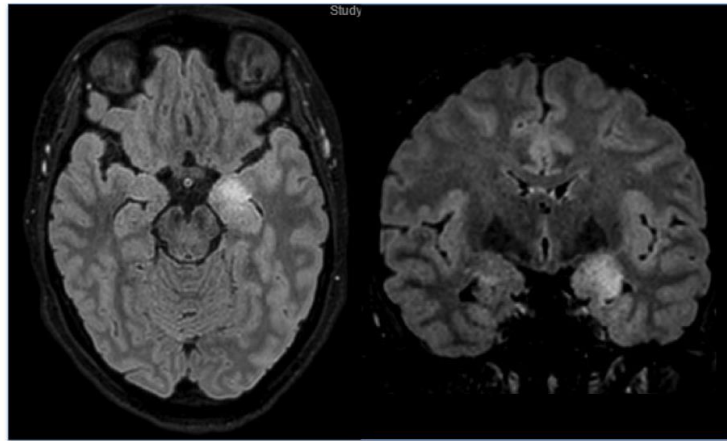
Unilateral hippocampus and amygdala hyperintensity in a patient with autoimmune encephalitis and anti-LGI1 antibodies (Brain magnetic resonance imaging, T2-weighted sequences, axial (left), and coronal view (right))
